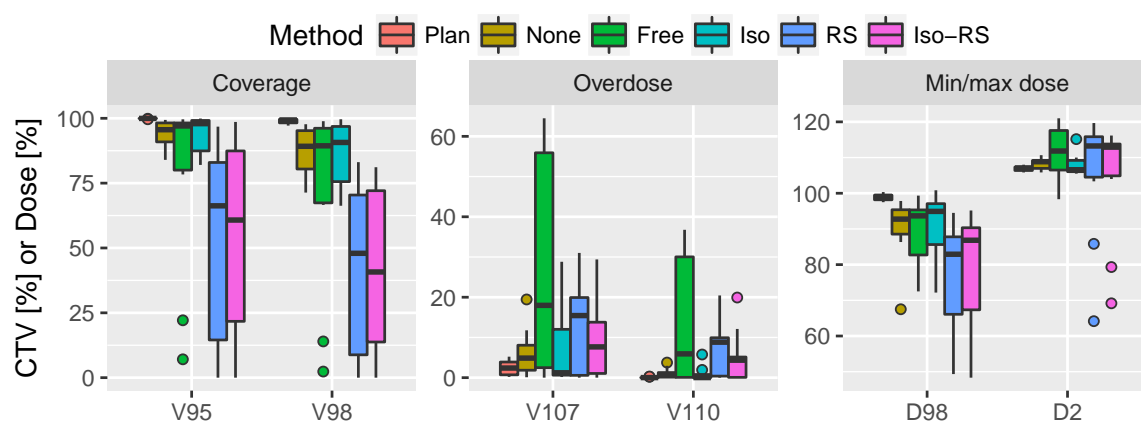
Performance of the cumulative dose of the geometrical adaptation method compared to the original plan and the original plan (Plan) delivered to the CBCTs (None). The geometrical adaptation methods are split into the implemented modes: free energy and position changes (Free), isocenter shifts (Iso), range shifters (RS) and the last two combined (Iso RS). The modes fail to reproduce the original plans values.
